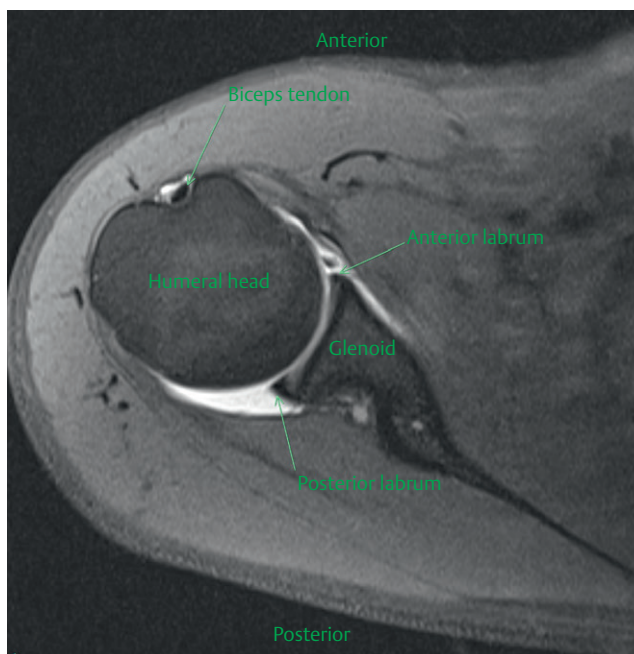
MRI arthrogram of the shoulder
